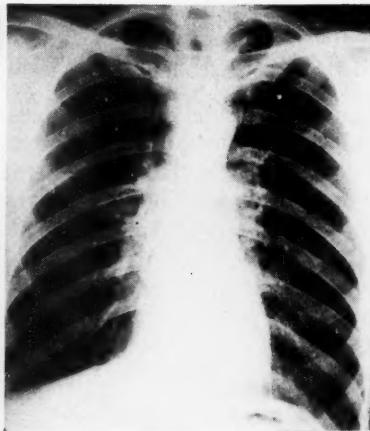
(Case 3). Normal x-ray of the chest in the presence of proven carcinoma. See text.
